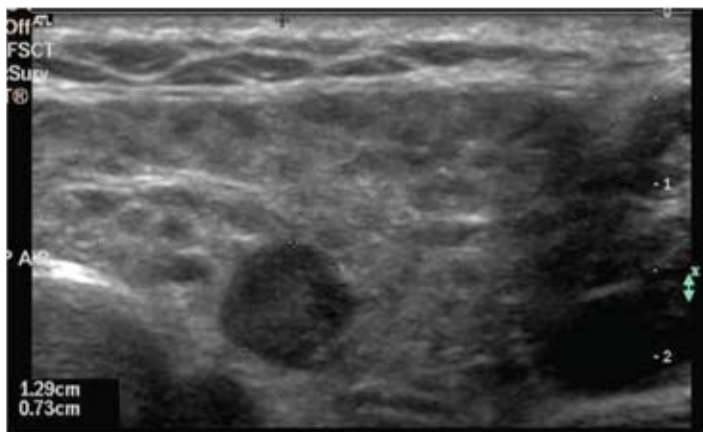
Ultrasound of parotid gland showing numerous small hypo-echoic foci and one large focus indicating possible lymphomatous change.
